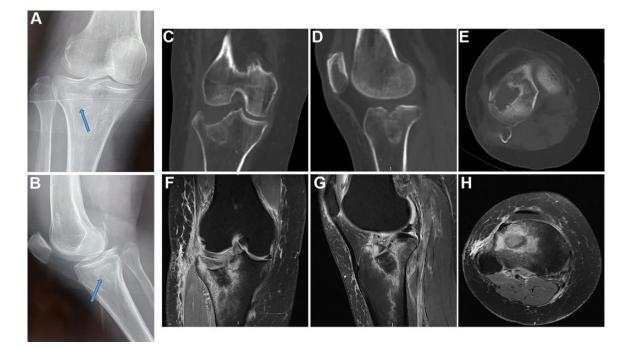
Preoperative images of a tibial plateau fracture on the right side of a 62-year-old female patient with a Schatzker type III tibial plateau fracture after a slip and fall. (A, B) Anteroposterior and lateral radiographs. Blue arrows indicate the fracture. (C) Coronal, (D) sagittal, and (E) axial CT scans. (F) Coronal, (G) sagittal, and (H) axial MRI scans. An MRI of the right tibial plateau revealed a Schatzker type III fracture with a grade 1 tear of the lateral meniscus and a grade I injury to the cartilage of the lateral femoral condyle. The integrity and continuity of the ACL, PCL, medial collateral ligament, and lateral collateral ligament were intact. ACL, anterior cruciate ligament; CT, computed tomography; MRI, magnetic resonance imaging; PCL, posterior cruciate ligament.
